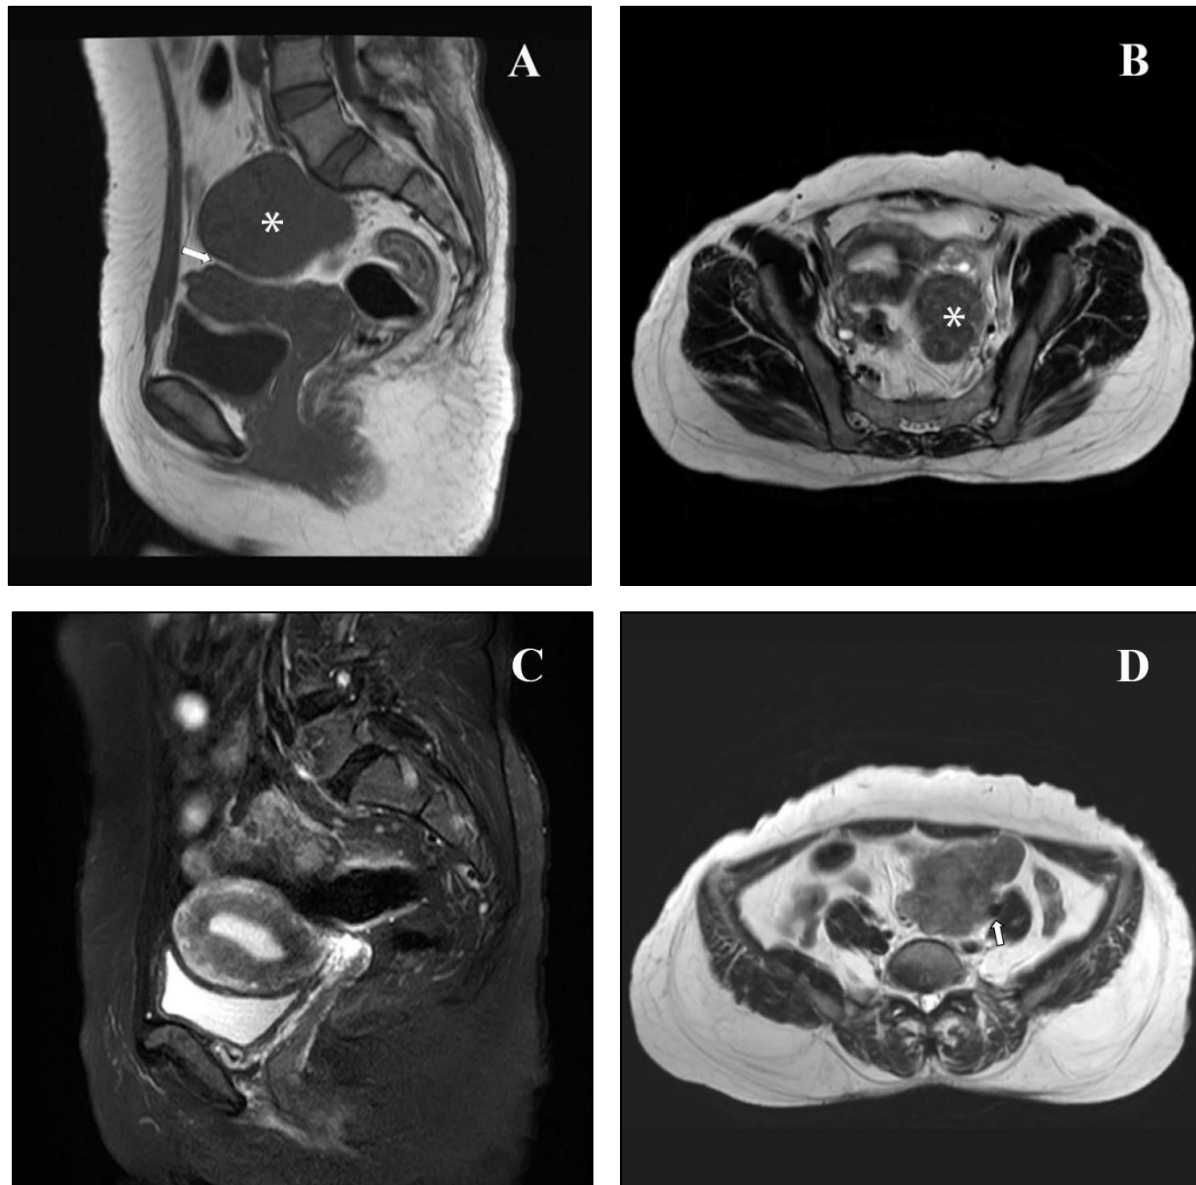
Magnetic Resonance Imaging (MRI) scan of the pelvis. (A) Sagittal T1-weighted image shows a well-defined mass (*) that is isointense to the myometrium, with a preserved thin hyperintense fat plane (white arrow) between the uterus and the mass. (B) Axial T2-weighted image demonstrates a pelvic mass (*) in the left posterolateral aspect of the uterus, isointense to the myometrium. Bilateral ovaries appear normal and are visible in the same section. (C) Sagittal T2 fat-suppressed image shows normal signal intensity of the myometrium and endometrium, with no focal uterine lesion. (D) Axial T2-weighted image at the level of the left common iliac artery bifurcation shows the mass abutting the medial wall of the vessel (arrow).
